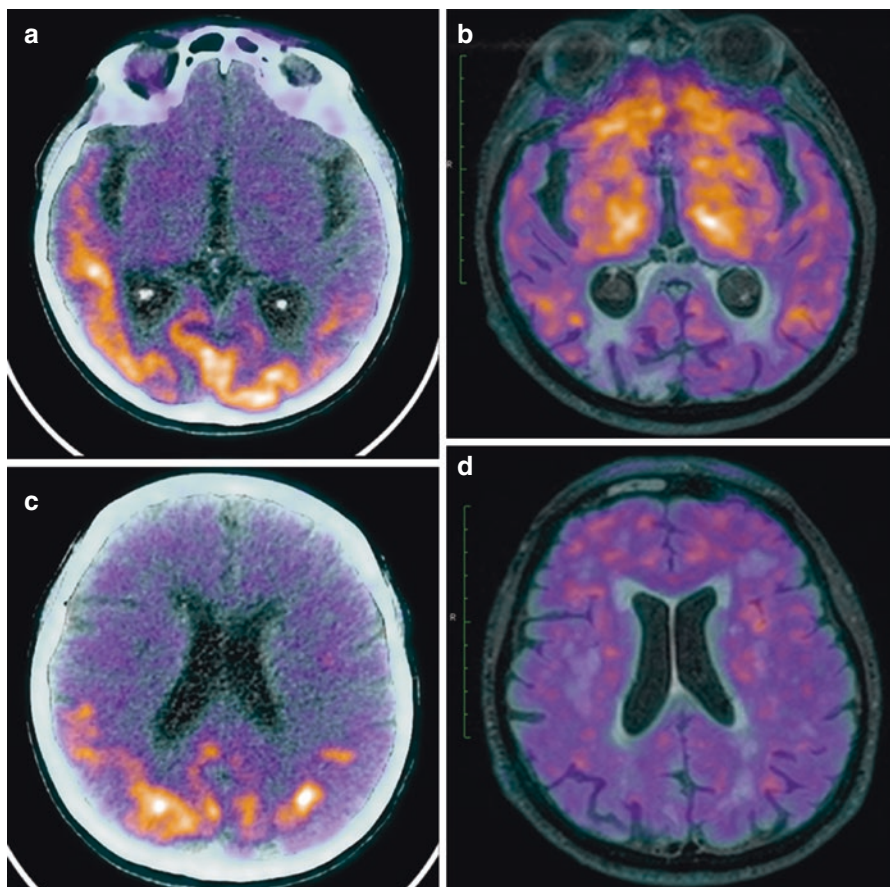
(a–d) Axial fused Tau tracer PET/CT (a, c) and axial fused amyloid PET/MR (c, d) in the same patient imaged 2 weeks apart demonstrated increased Tau tracer uptake in the posterior parietal and occipital regions of the brain cortex (a, c) with amyloid PET showing completely different regions of amyloid deposition in the frontal lobes (d).
